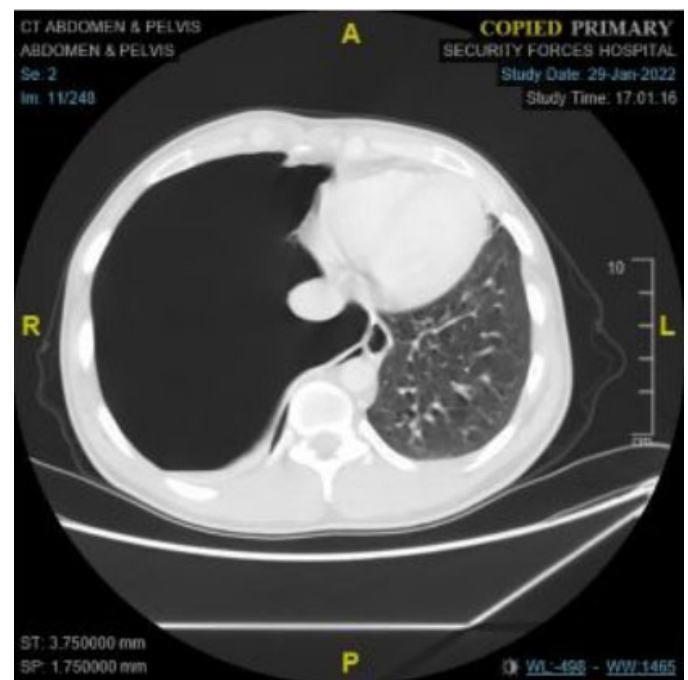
The CT scan of the patient's upper abdomen which shows large pneumothorax pushing the mediastinum to the left side. This is the first CT abdomen which was ordered to rule out appendicitis.
